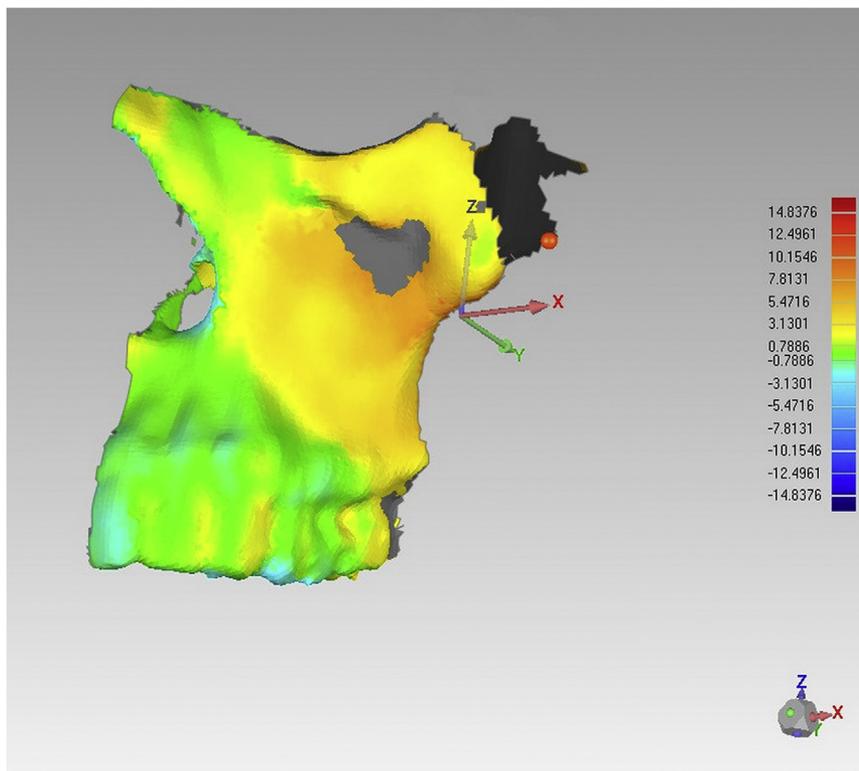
Accuracy evaluation. The color-coded map shows the degree of discrepancy between preoperative design and postoperative CT, computed tomography.
